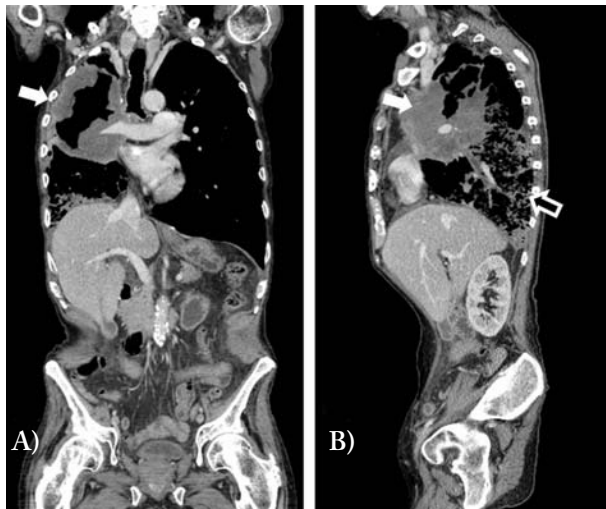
Coronal (A) and sagittal (B) views on the computerised tomography (CT) scan of the chest and abdomen. There is a right upper lobe lesion with extensive cavitation (white arrow). Extensive right lower lobe consolidation and ground glass opacification is consistent with pneumonia (black arrow). There is clear evidence of overall cachexia.
